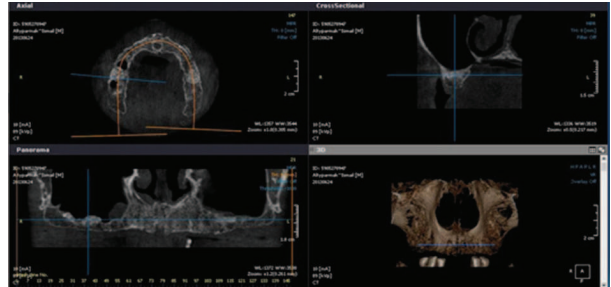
CBCT 9 months after the right operation and 6 months after the left
